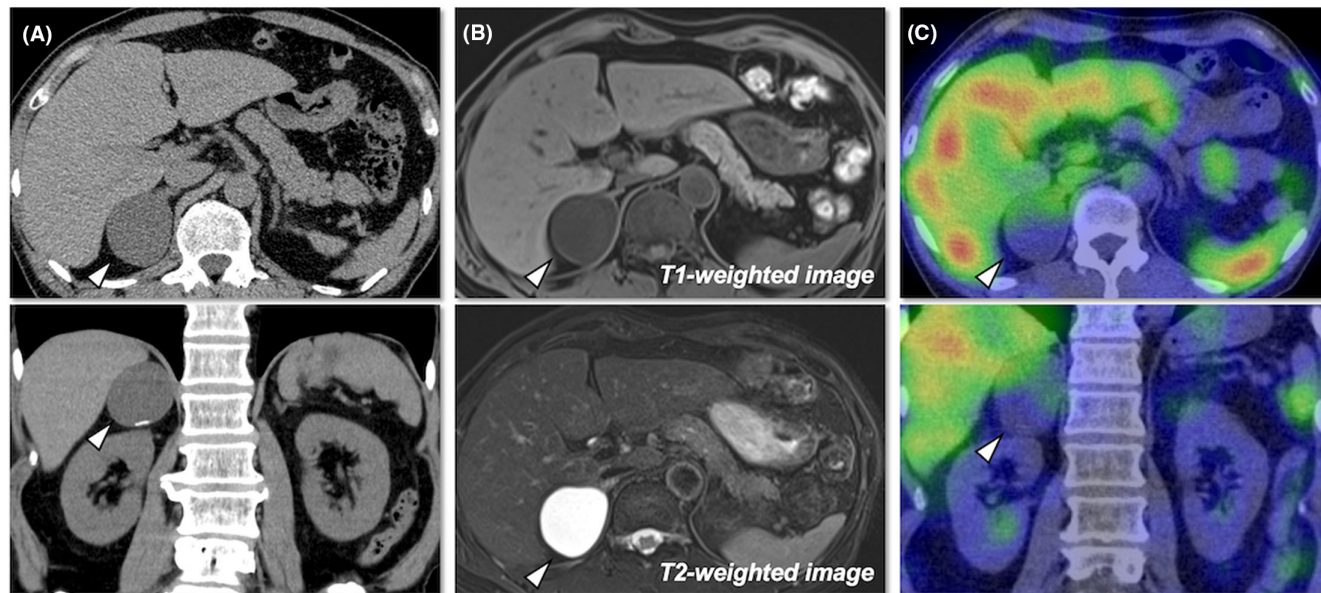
(A) Computed tomography revealed a right adrenal tumor with slight calcification (arrowheads). (B) Chemical shift magnetic resonance imaging in the adrenal lesion showed hypointensity on T1- and hyperintensity on T2-weighted sequences (arrowheads). (C) ¹²³I-metaiodobenzylguanidine scintigraphy did not show accumulation in the right adrenal tumor (arrowheads).
